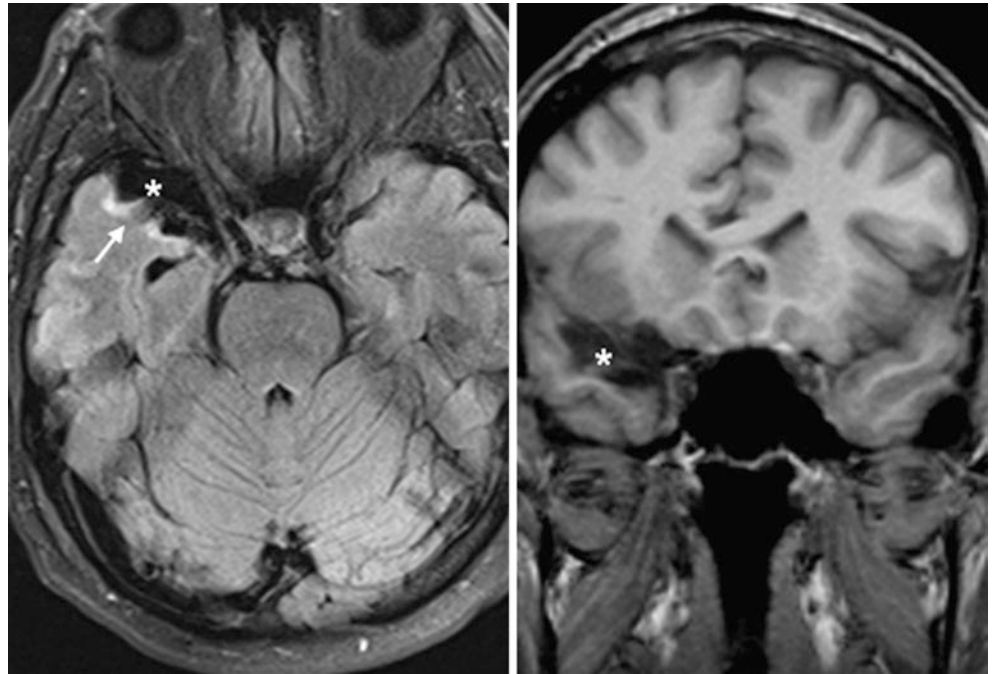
A 3T MR axial FLAIR (*left*) and coronal T1WI (*right*) of a 50 year old showed an AC-like focus (*), but the presence of gliosis on FLAIR (*thin arrows*) and enlargement of the adjacent temporal horn confirmed that this is atrophy
